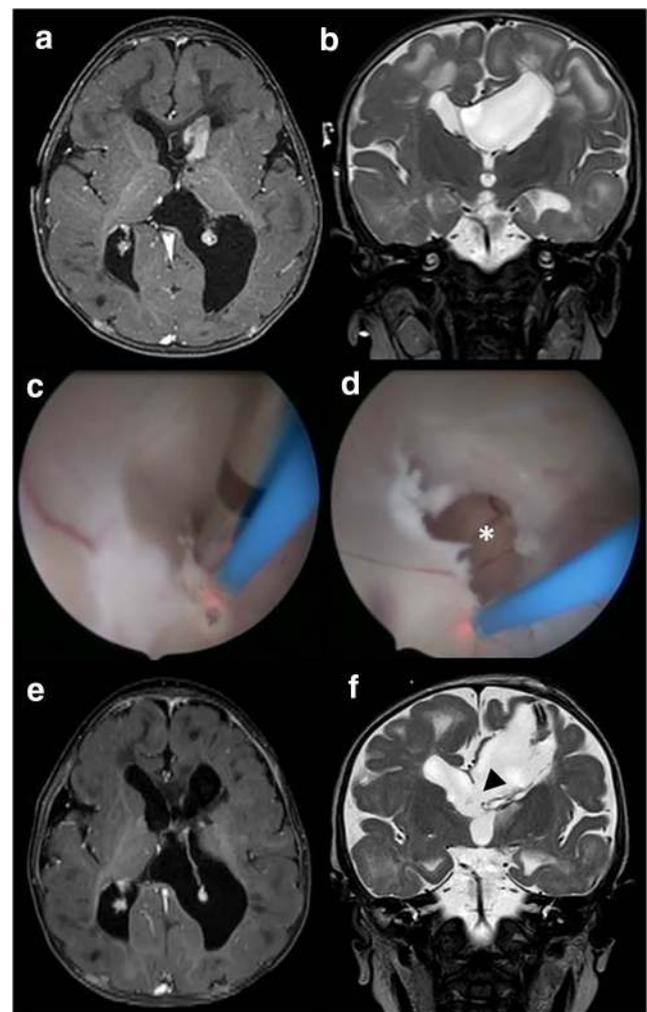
1-year-old girl with progression of left residual SEGAs (a) and trapped lateral ventricle (b). Tumor was resected endoscopically with the aid of NICO Myriad® (NICO Corporation, Indianapolis, IN) and thulium laser (RevoLix™, LISA laser products OHG, Germany) (c); septostomy was also performed (d, asterisk). Postoperative axial T1-weighted after contrast administration MR image confirming the total removal of the tumor (e) and coronal T2-weighted MR image documenting the patency of the septostomy (f, arrowhead)
